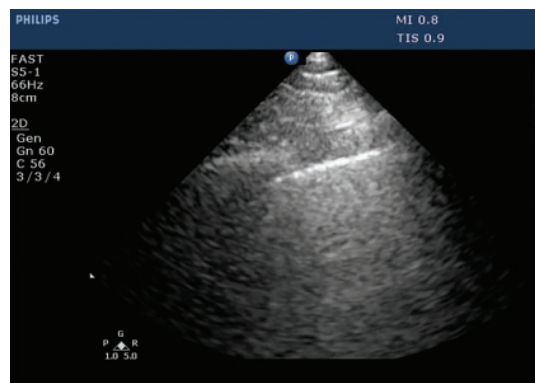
A lines. The A-line pattern occurs in normal lung and in pneumothorax. Ultrasound waves (arrows) reflect off the pleural interface repeatedly, producing repeated horizontal lines throughout the field.
